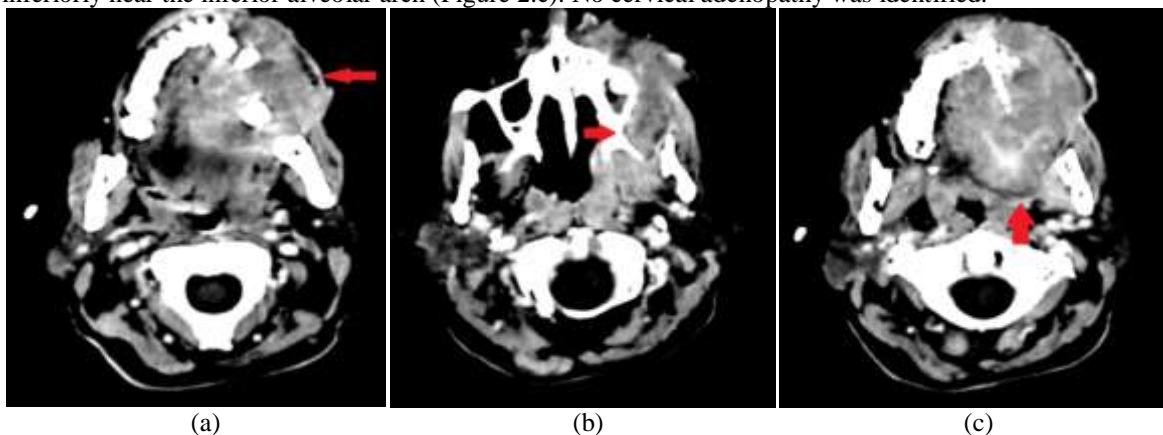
computed tomography (CT) scan showing locally advanced oral Kaposi's sarcoma invading Jugal soft tissues and upper left alveolar arch (a), with maxillary bone lysis (b), arriving to parapharyngeal space and the floor of the mouth (c).
